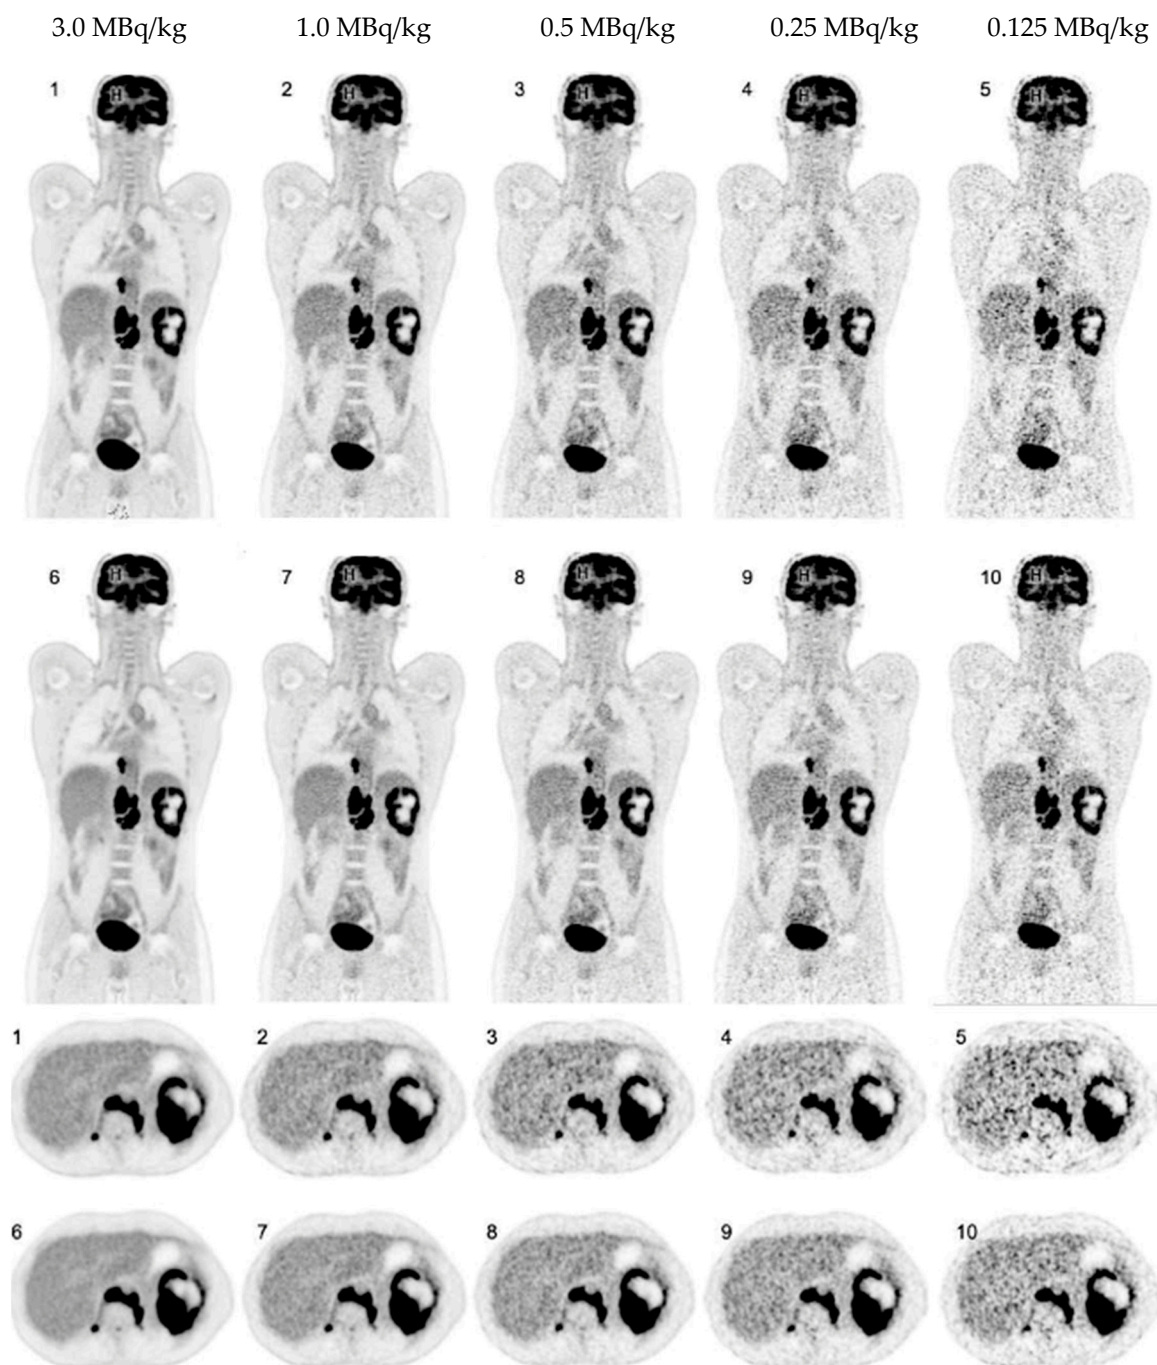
Coronal and axial [^{18}F]FDG PET images of a 37-year-old patient with Hodgkin lymphoma reconstructed in HS (1-5) and UHS (6-10) mode.
